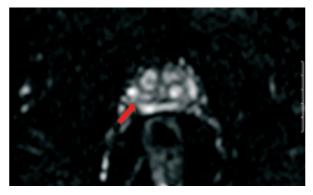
DWI shows decreased diffusion of water molecules in the pointed region (red arrow). MR guided biopsies from this region demonstrated prostate cancer.
